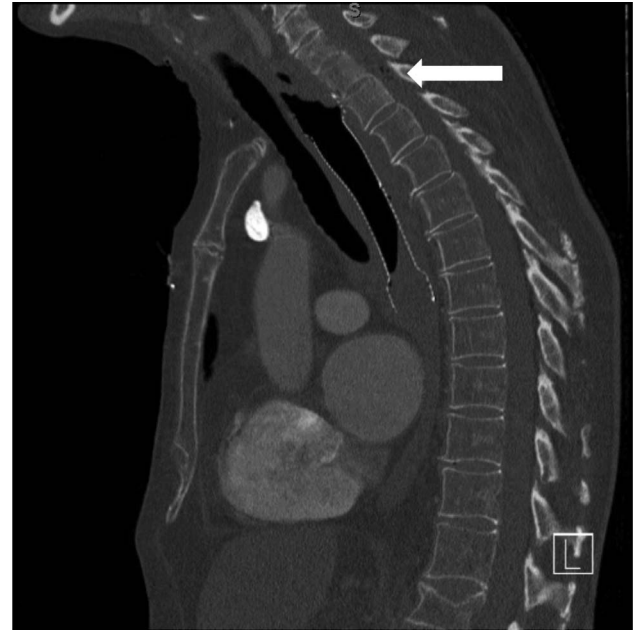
Chest computed tomography showing the presence of small gas locules within the spinal canal (arrow) before stent exchange.
